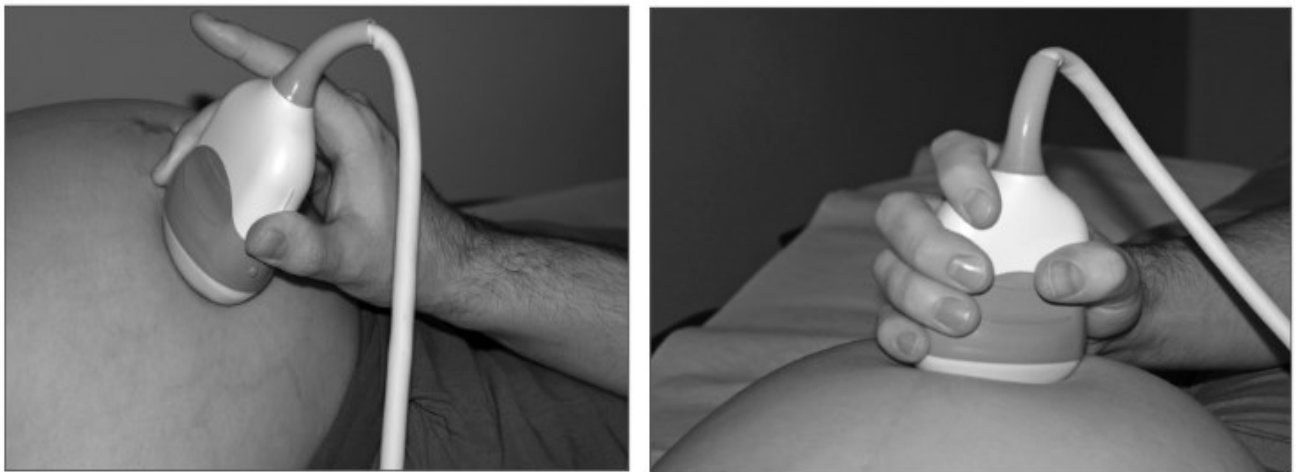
The two types of grips employed by ultrasonographers on ultrasound probes. Left: Pinch grip; not recommended. Right: Palmar, or power grip; deploys greater force and can lessen muscle tiredness [3]. Reprinted with permission from The Associati
